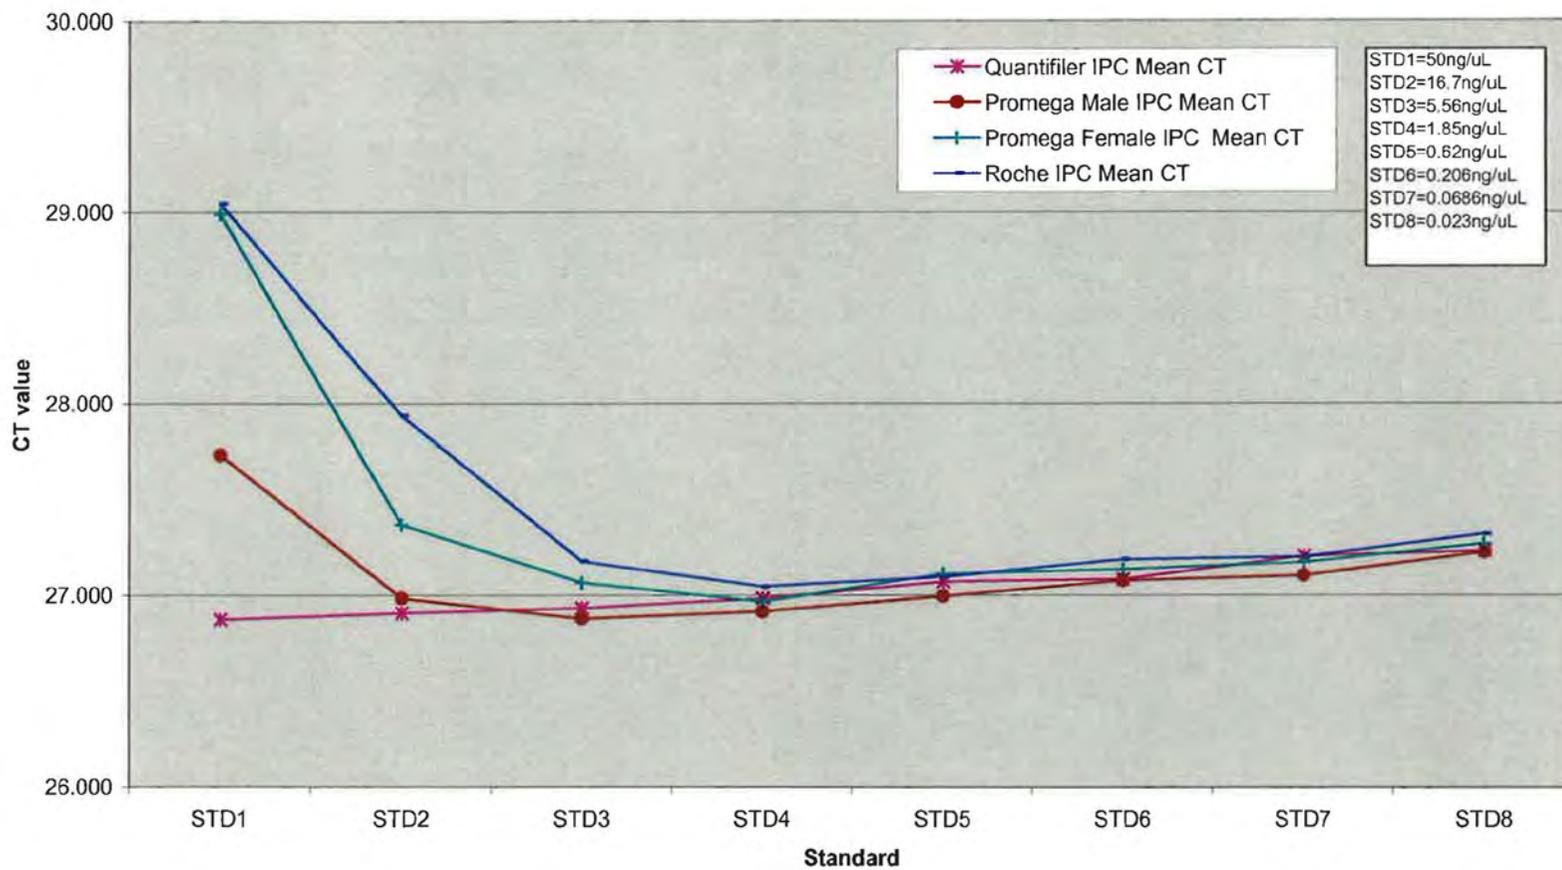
Distribution of mean IPC CT values.
